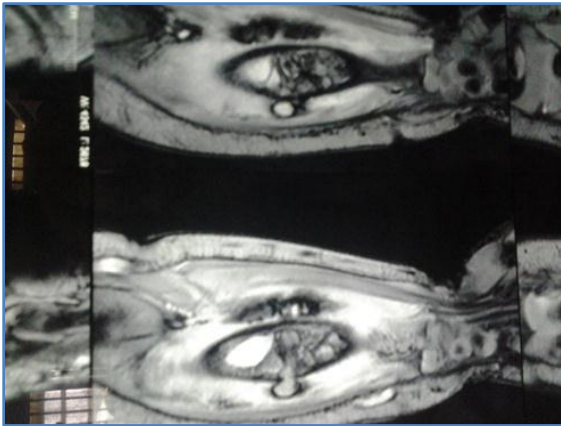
A MRI showed normal soft tissues with oedema and cystic lesion
